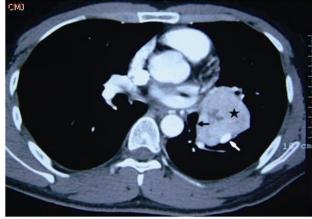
Comparison CT scans of the chest showing a left hilar mass (Feb 14, 2009) measuring 5 cm, and the same hilar mass measuring 2 cm 1.5 months later (Mar 31, 2009). LUNG CANCER IS REDUCING IN SIZE.
